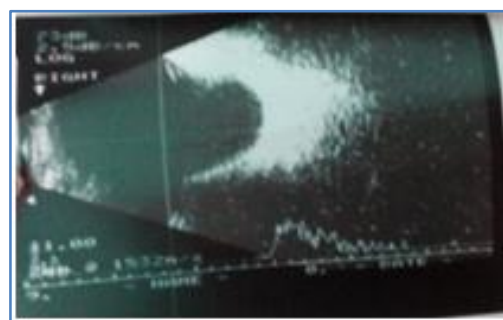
Ultrasonography of the globe showing Posterior staphyloma
